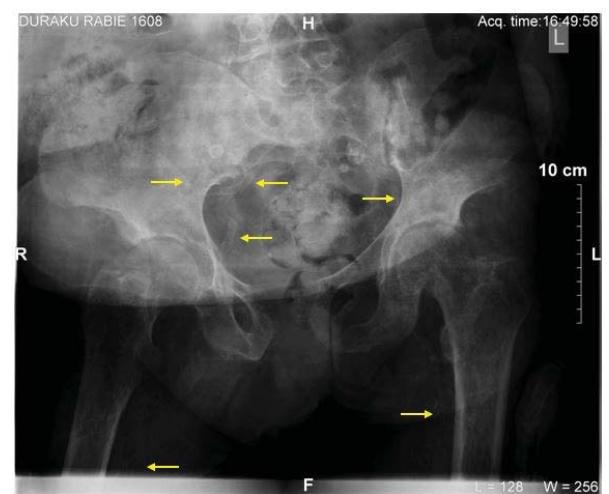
Plain X-ray of pelvis. Arrows show calcification of both femoral arteries and iliac vessels.
